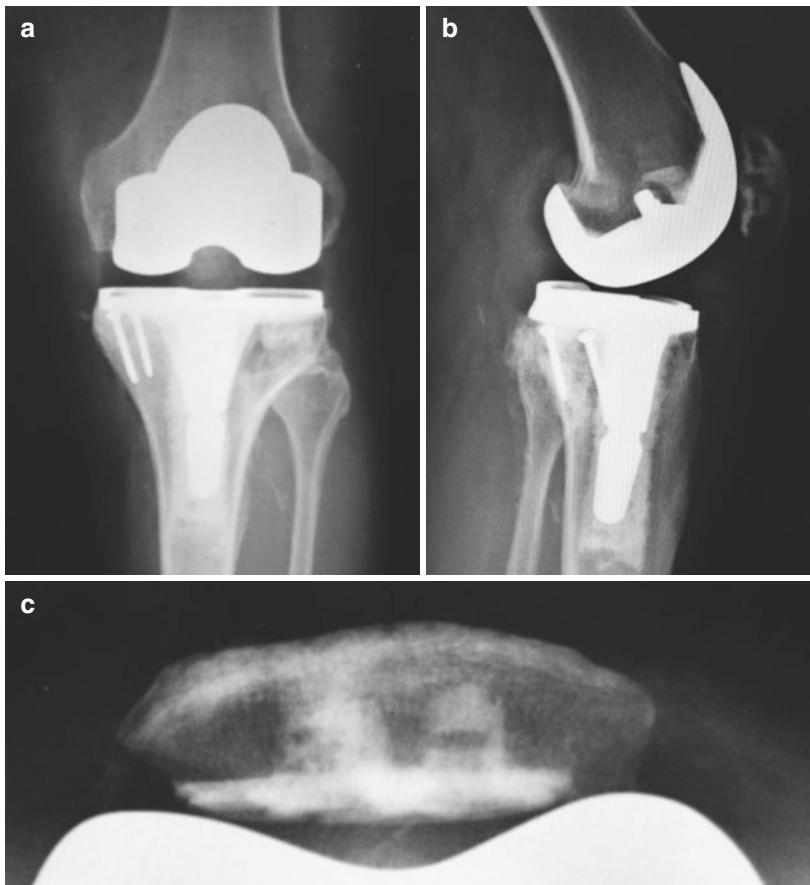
Final (a) anteroposterior, (b) lateral, and (c) and Merchant X-rays
